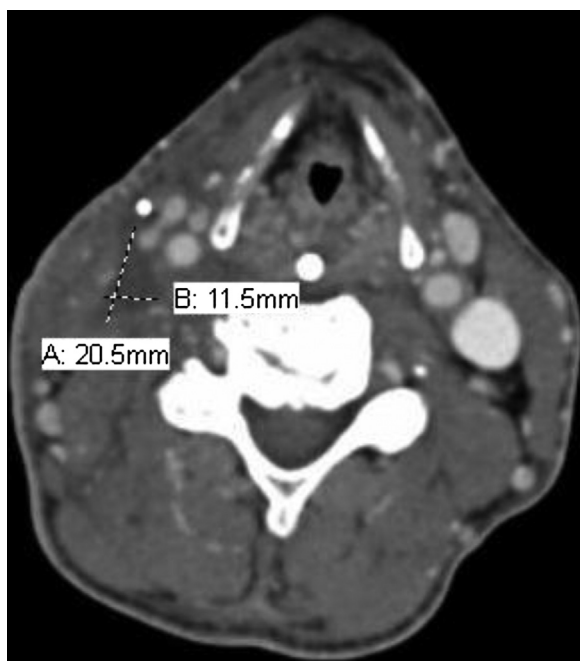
CT of head and neck.
